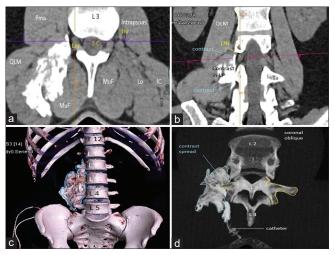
(a) (Axial view) (b) (Coronal view) showing spread of contrast along Lnr. (Pma – Psoas major; Lnr – Lumbar nerve root; SC-Spinal cord; QLM-Quadratus Lumborum; Muf – Multifidus; Lo-Longissimus; IC-Iliocostalis) (c) CT-Volume rendering technique. Blue outline – Contrast spread behind transverse process (orange outline). (d) Axial Oblique view showing spread of contrast across L3 -4 and close to L3 Lnr
